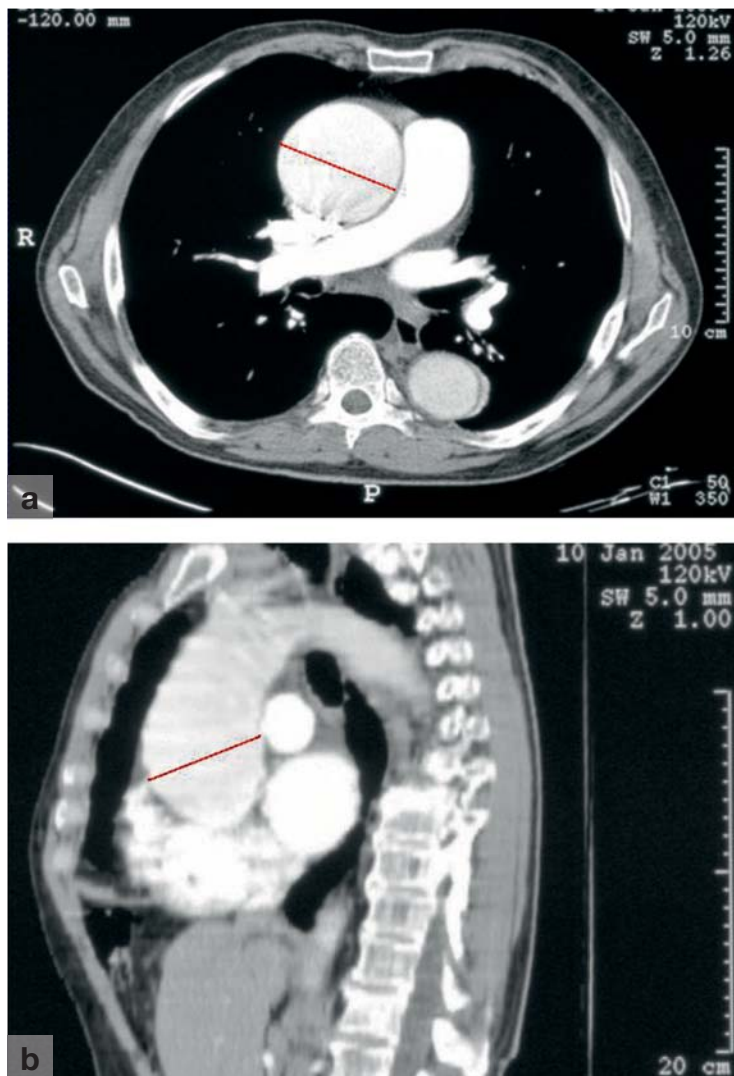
Measuring aortic diameter on computed tomography
